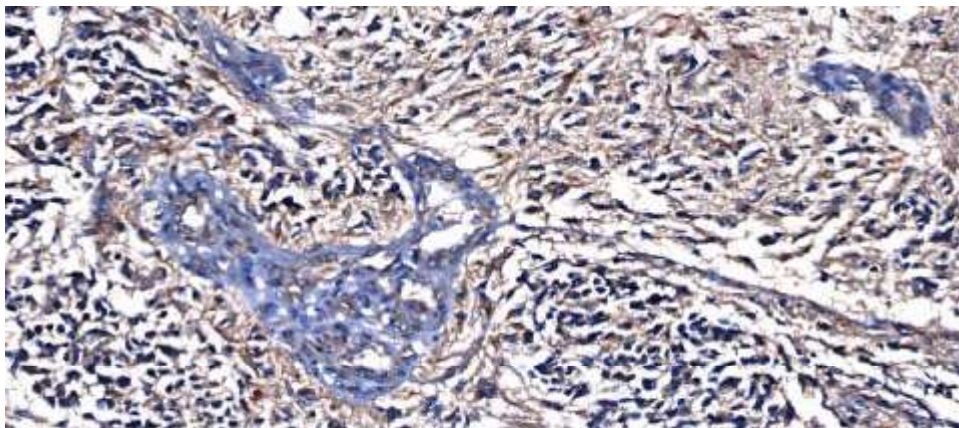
GB showing glomeruloid body formation, with cytoplasmic and membranous endothelial cells PSMA expression. Original magnification power 200x
